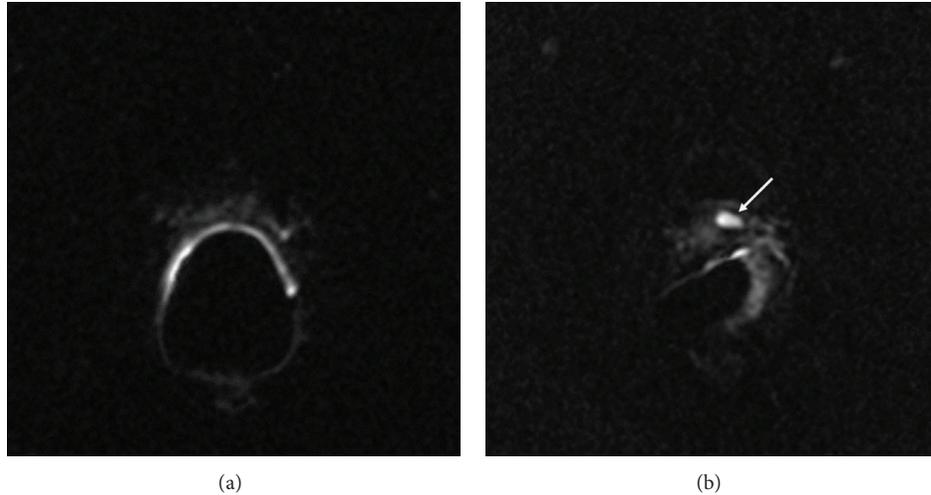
DWI qualitative scoring. The observers attributed score 0 to the absence of clear-cut hyperintense lesion in the PF area (a) and score 1 to a focal hyperintensity (arrow, (b)) attributable to a relapse.
